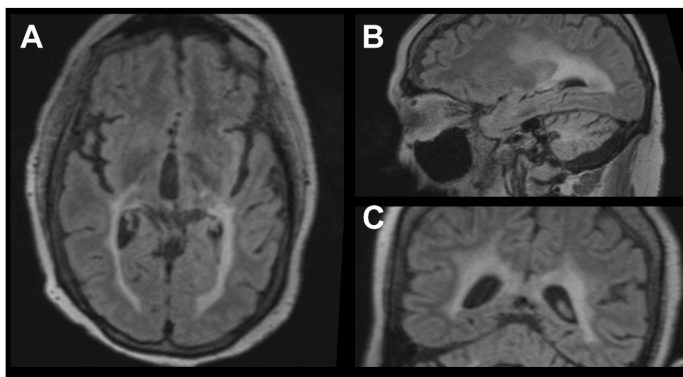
Adrenoleukodystrophy involving the optical radiations. Axial (A), sagittal (B), and coronal (C) FLAIR imaging in a case of adrenoleukodystrophy showing extensive involvement of the white matter tracts of the optical radiations.
